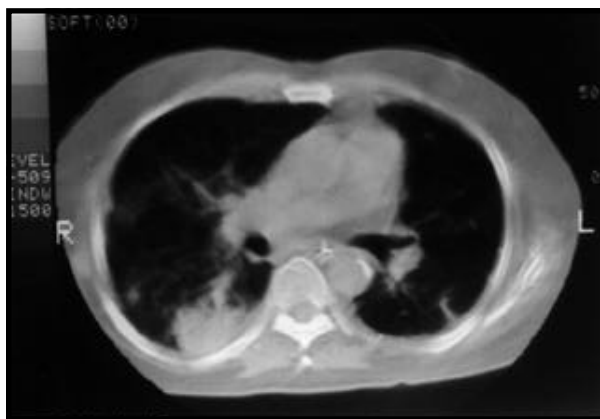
Chest CT scan showing infiltration of the right and left lung.
